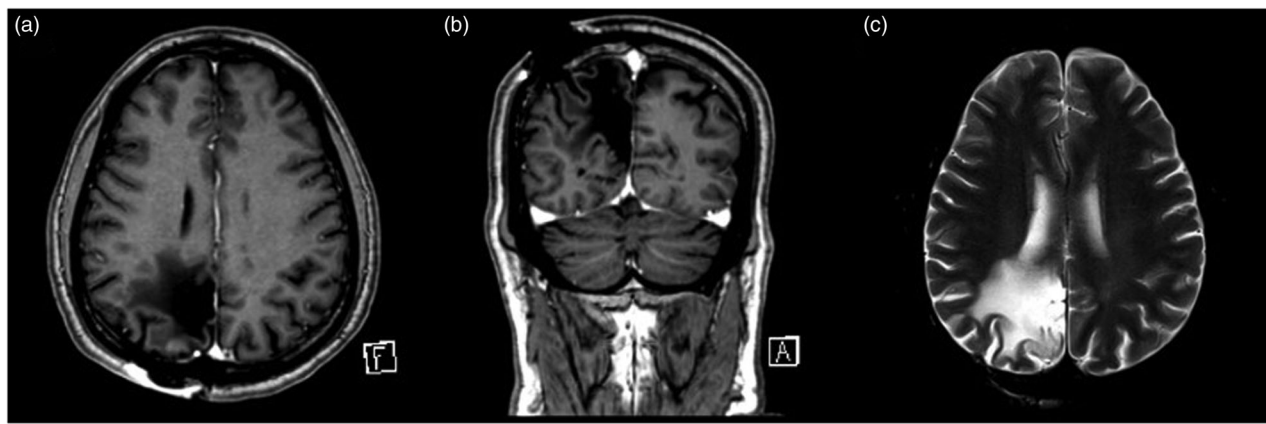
Postoperative T1w axial (a) and coronal (b) MR images with gadolinium and T2 flair image (c), showing no tumour recurrence after 13 years but persistence of gliosis.
